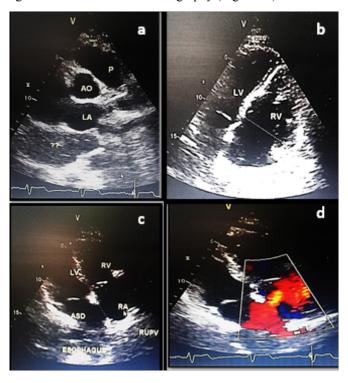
Transthoracic echocardiographic views of the patient (a) Arasternal short axis view revealing an unknown organ beside the left atrium; (b) 4 chambers view revealing right ventricle dilatation, (c) 4 chambers view revealing the ASD and the esophagus; (d) Subcostal view revealing ASD; P=Pulmonary Artery, Ao=Aorta, LV=Left Ventricle, RV=Right Ventricle, ASD=Atrial Septal Defect, RUPV=Right Upper Pulmonary Vein
